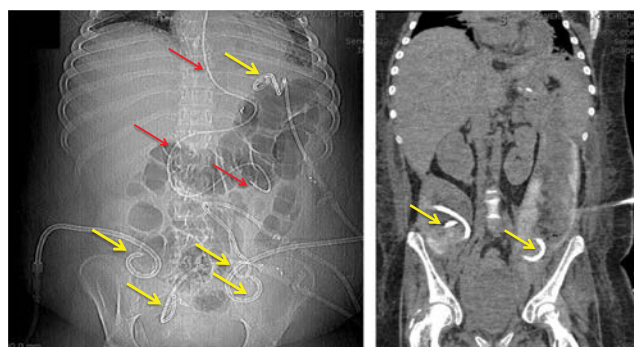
Abdominal x-ray and CT scan image of extensive pancreatic and peripancreatic necrosis (not encapsulated) extending toward the pelvis with five percutaneous drains (yellow arrows) and a naso-jejunal feeding tube (red arrow).
